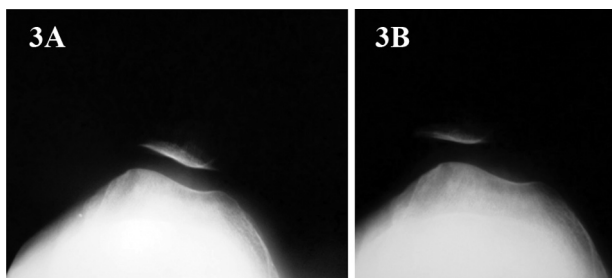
A: Axial knee radiograph;
